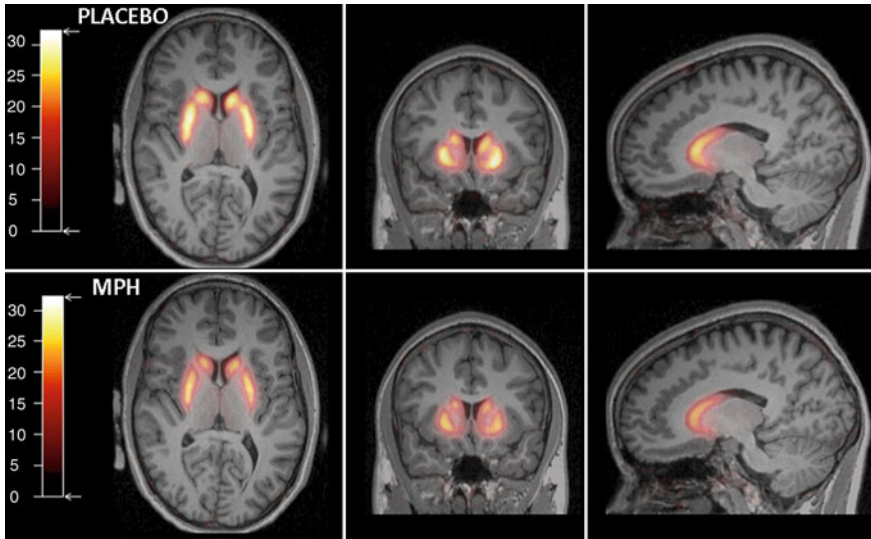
[^{18}F]fallypride BP_{ND} maps of a healthy control following placebo (*top row*) and following oral MPH (*bottom row*). BP_{ND} maps are superimposed on a high resolution magnetic resonance image. MPH increases endogenous DA, leading to a reduction in [^{18}F]fallypride BP_{ND}
